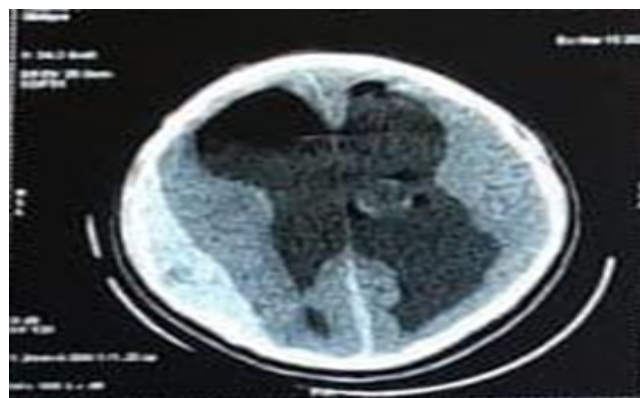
CT brain showing right side acute subdural hemorrhage, with compression of the ipsilateral ventricle.
